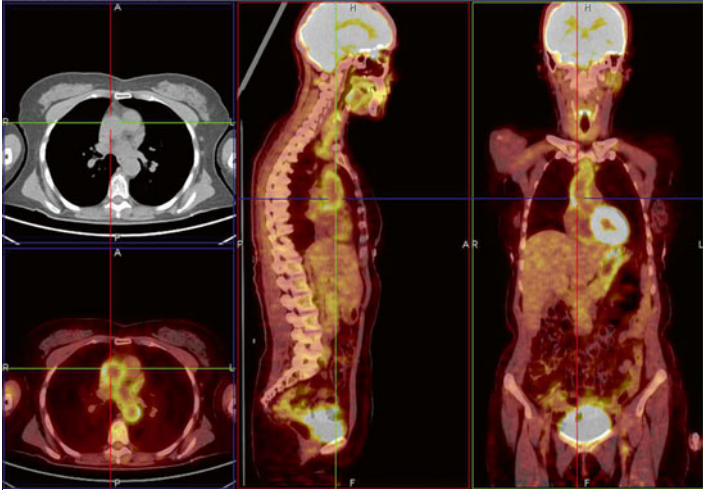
18FDG-PET-CT showing hyper-uptake at the level of the ascending aorta. Such levels of uptake are highly indicative of aortitis; lower levels may be associated with atherosclerotic lesions, whereas the normal has no detectable uptake (Courtesy of Drs M. Bifulco and F. Porcaro, Nuclear Medicine Diagnostics Unit of the Monaldi Hospital, Naples, Italy)
